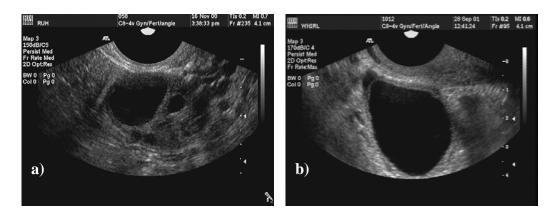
Ultrasonographic images of a natural cycle and OC cycle follicles. (a) Natural cycle follicle on Day 0, (b) OC cycle follicle on Day 0.
